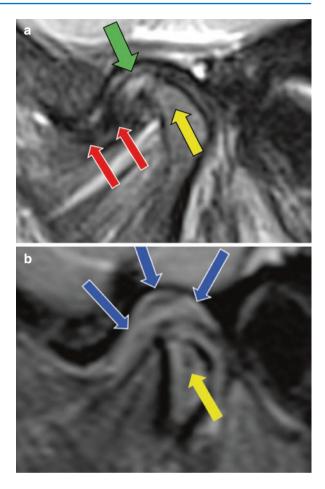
MRI of TMJ demonstrating adolescent internal condylar resorption (AICR) with condylar resorption and an anterior displaced articular disc. These discs can become nonreducing relatively early on in the process. Note the thinness of the cortical bone on the superior surface of the condyle and amorphous tissue surrounding the condyle
